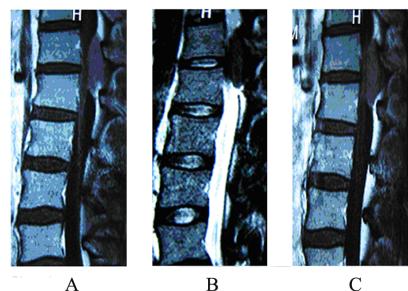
MRI studies at the level of the T12-L1 disc space demonstrating the posterior epidural mass with near total obliteration of the spinal canal. (A): T1-weighted MRI scan; (B): T2-weighted MRI scan; (C): T1-weighted gadolinium-enhanced MRI scan.
